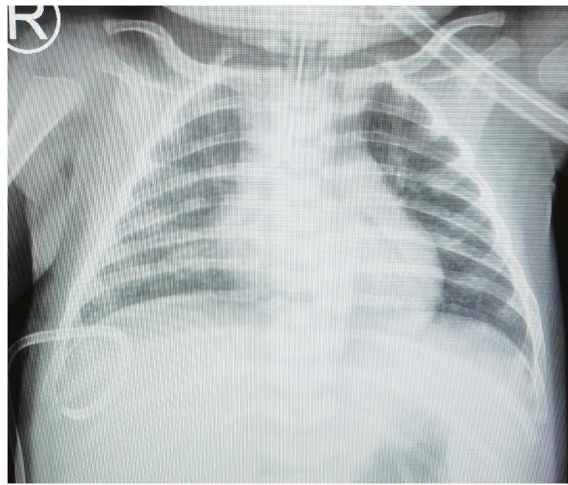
Chest X-ray before endotracheal tube extubation.
